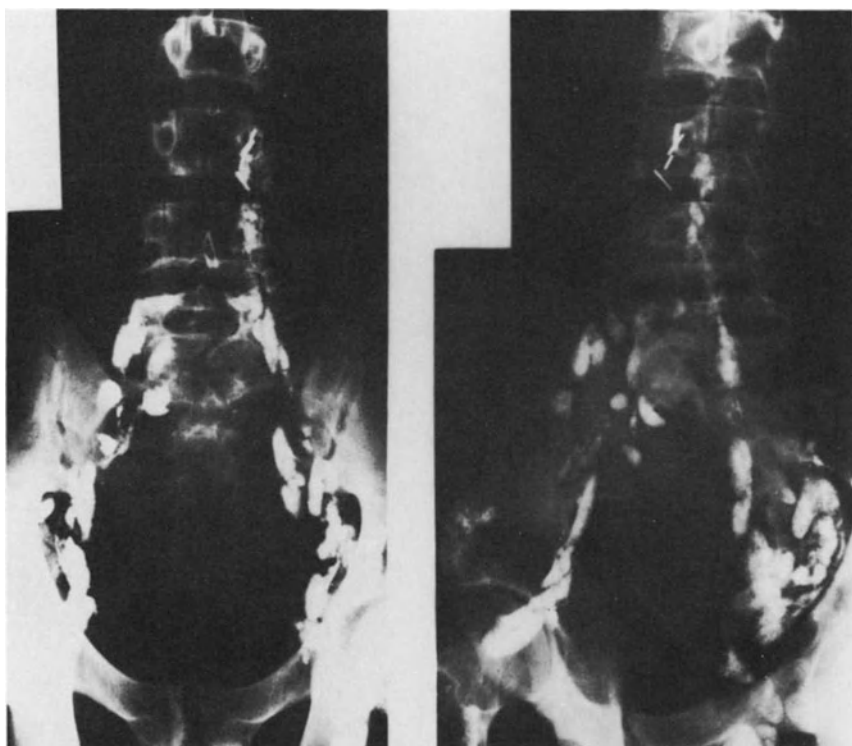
A lymphogram in a 15-year-old boy with supradiaphragmatic Hodgkin's disease demonstrating uniformly enlarged foamy lymph nodes, all with a reactive appearance, representing reactive hyperplasia. A CT scan of these nodes is capable of visualizing the abnormally enlarged lymph nodes, but not the architectural pattern demonstrating their reactive appearance.
